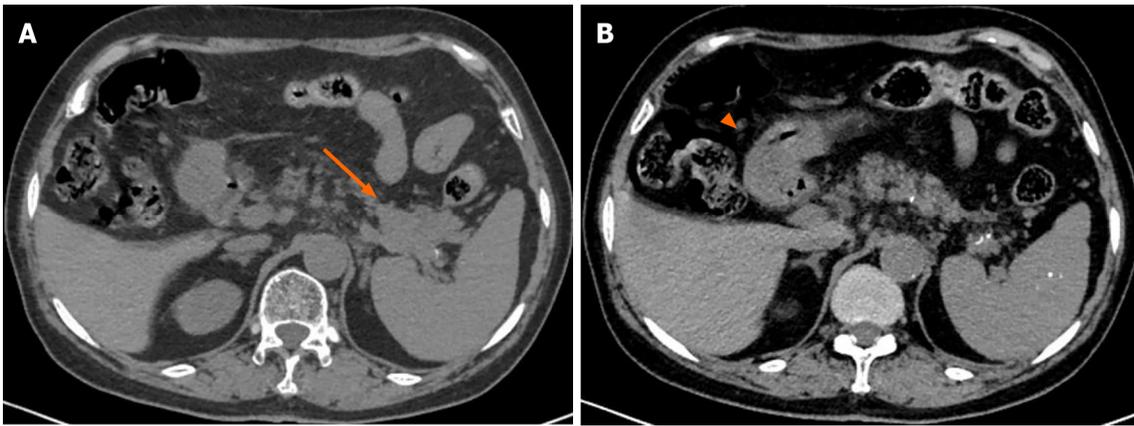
Upper abdominal computed tomography images. A: A lobulated solid mass (orange arrow) in the cauda pancreas invading the splenic pedicle; B: The gastric antrum is full of chyme, and the accurate condition of the gastric wall is not clear (orange arrowhead).
